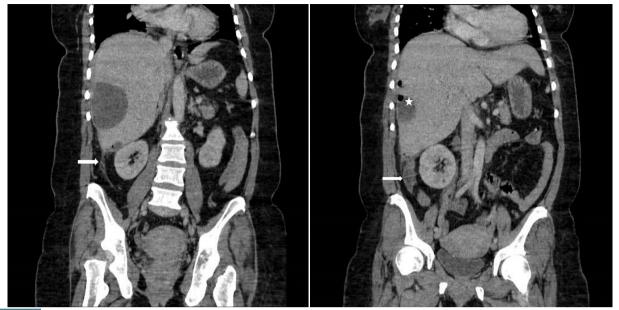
CT scan with IV contrast (coronal reconstruction slices) showing inflamed appendicitis in the inferior border of liver with fat stranding (arrows), as a cause of liver abscess which is a hypodense lesion with air focuses (star)
